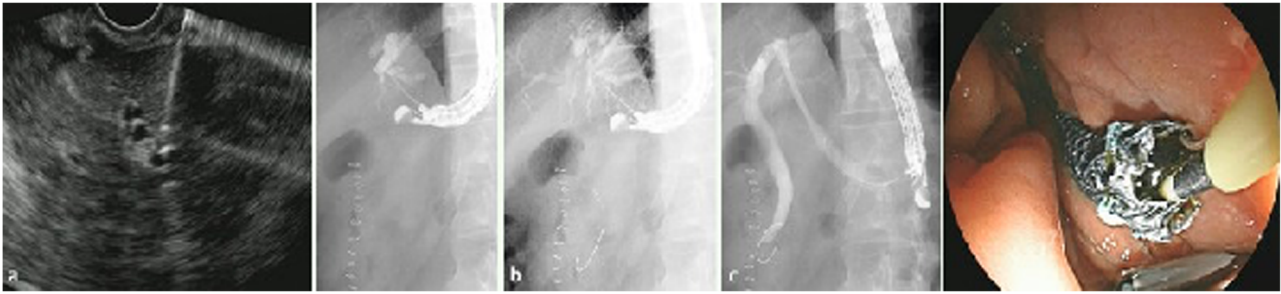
EUS and Fluoroscopic images showing the deployment of a long pcSEMS during Hepaticogastrostomy. *Endoscopy, Safety and effectiveness of a long, partially covered metal stent for endoscopic ultrasound-guided hepaticogastrostomy in patients with malignant biliary obstruction*, 48, 2016, p. 1125–1128, Yousuke Nakai, Hiroyuki Isayama, Natsuyo Yamamoto, Saburo Matsubara, Yukiko Ito, Naoki Sasahira, Ryunosuke Hakuta, Gytane Umefune, Naminatsu Takahara, Tsuyoshi Hamada, Suguru Mizuno, Hirofumi Kogure, Minoru Tada, Kazuhiko Koike, (© Georg Thieme Verlag KG Stuttgart · New York) “With permission of Thieme”.
